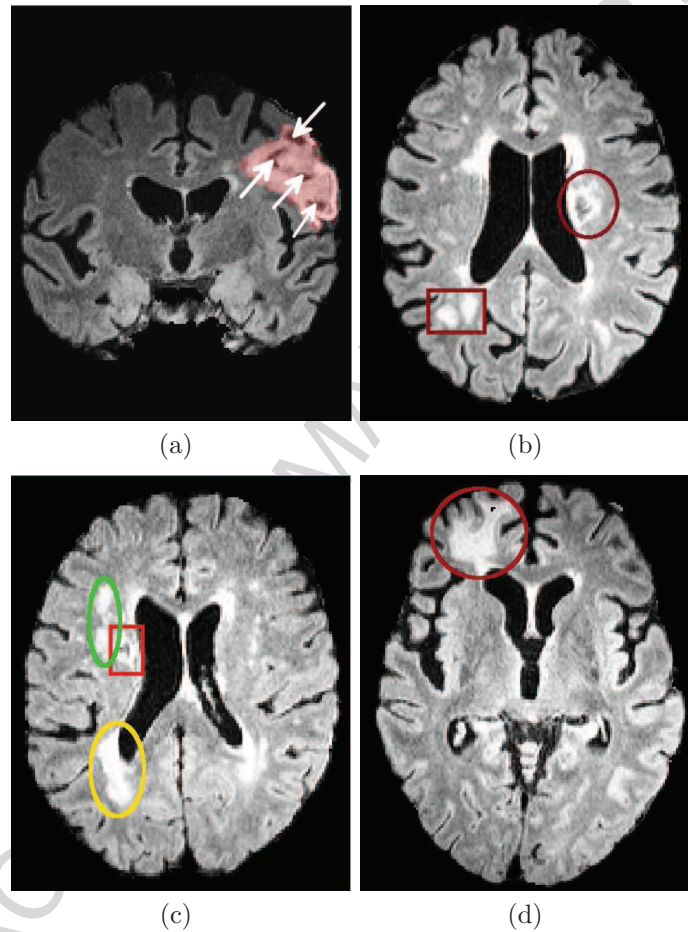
Stroke lesions at the chronic stage with associated white matter hyperintensities on FLAIR showing similar tissue contrasts. (a) Heterogenous intensities within the chronic stage stroke lesion due to gliosis. The light red mask denotes the entire stroke area as marked by an expert, while the arrows show possible necrosis or atrophy with CSF involvement; (b) anomalous FLAIR hyperintensities. The circular region in the image depicts a stroke region while the square area contains other white matter hyperintensities; (c) the square area delineates a stroke, while the oval areas are WM lesions. The stroke in the red square has a tendency to fuse with the WM lesion in the green oval region. The yellow oval region indicates large WM lesion load around the periventricular region; (d) large secondary/pre-existing stroke lesion in the frontal lobe which is not a primary stroke but has similar intensities.
